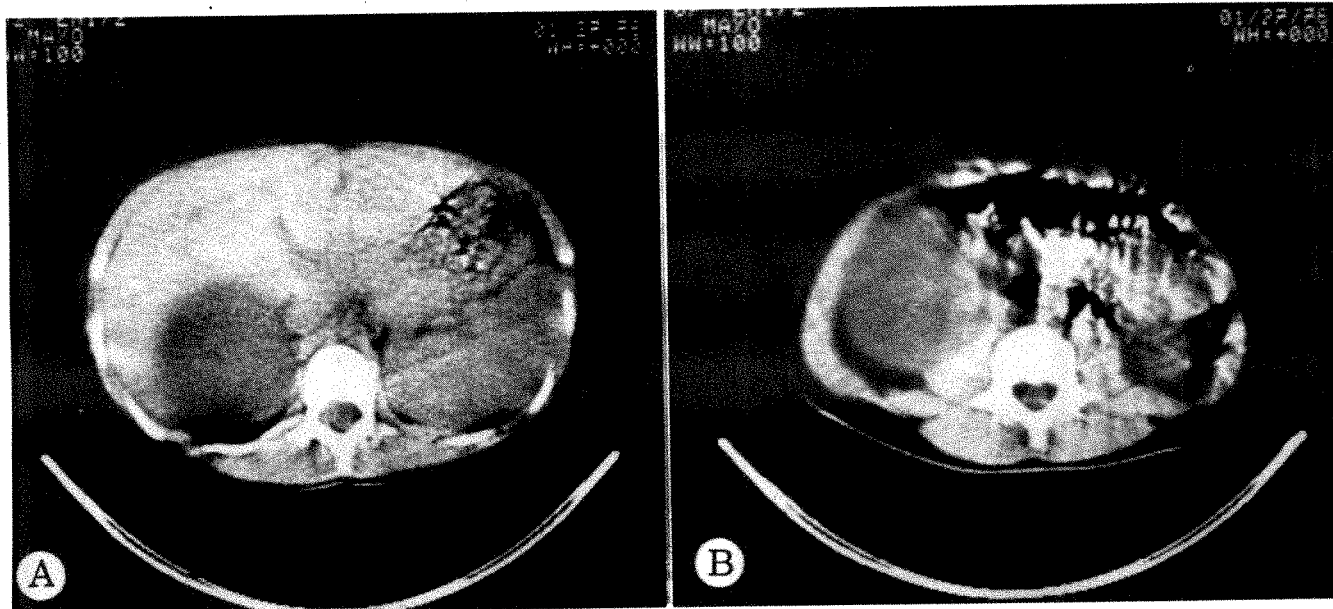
CT scans of 5-year-old boy with palpable right flank mass. A, Large, sharply circumscribed low density mass in area of right kidney posterior to liver. (Absence of substantial intraabdominal fat makes identification of intraabdominal organs difficult in children.) B, Scan through lower portion of large right flank mass showing homogeneity of density within mass. No renal tissue on right identifiable on scans. Hydronephrosis with complete destruction of right kidney secondary to congenital ureteropelvic junction obstruction found at operation.
